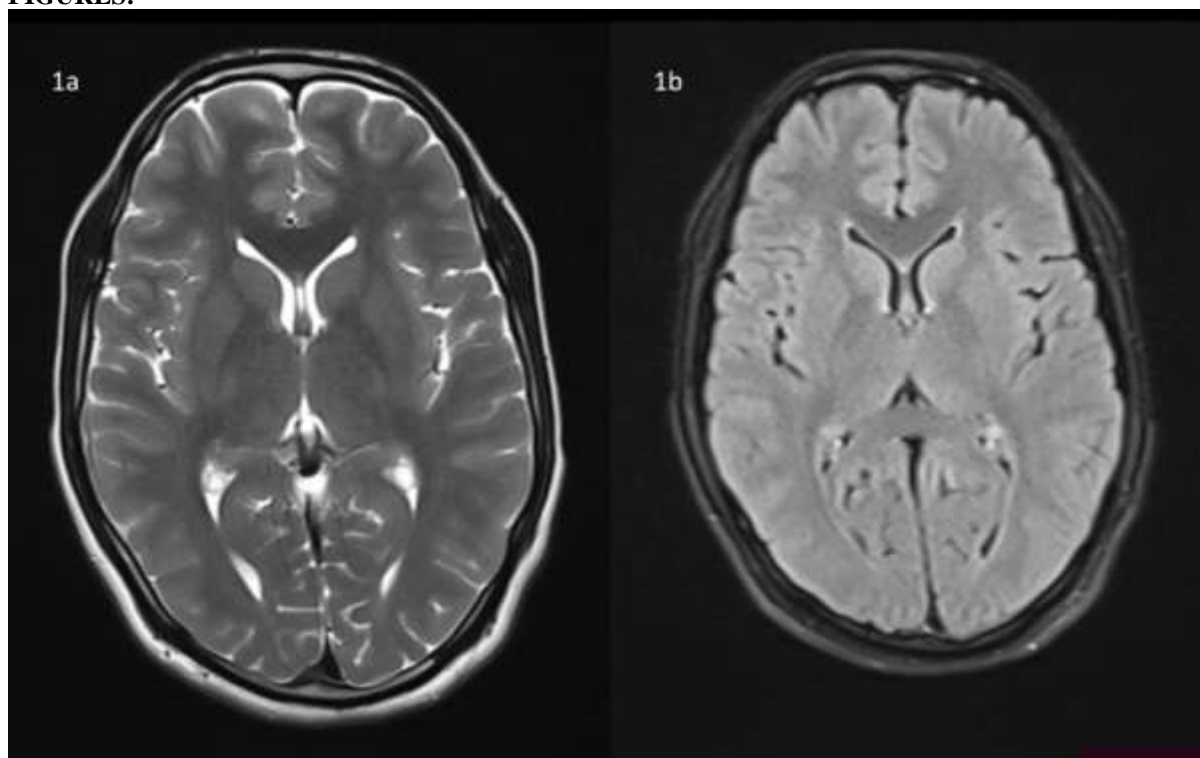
T2 weighted (1a) and FLAIR (1b) axial images revealed normal study for brain parenchyma
